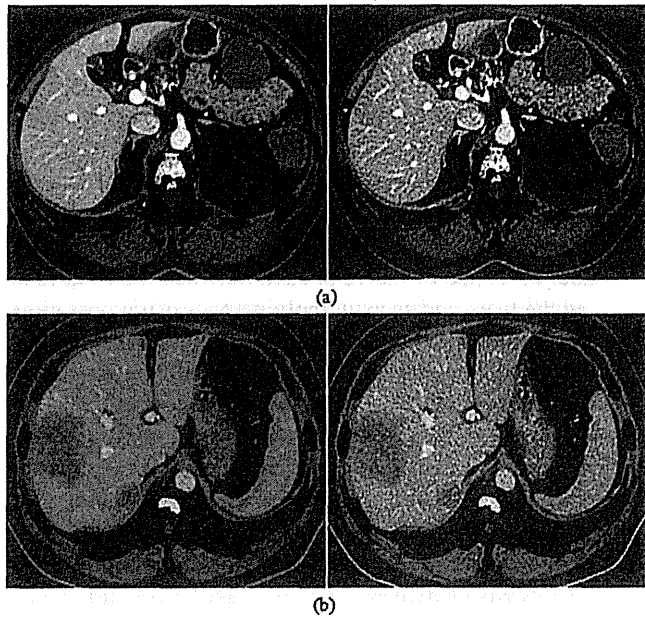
Enhancement of peripheral blood vessels is achieved using 3D bias field correction. (Left) CT image before enhancement and (right) after enhancement. (a) A nonlow intensity tumor (NLIT) case (MICCAI-training-15) and (b) a LIT case (MICCAI-training-16).
